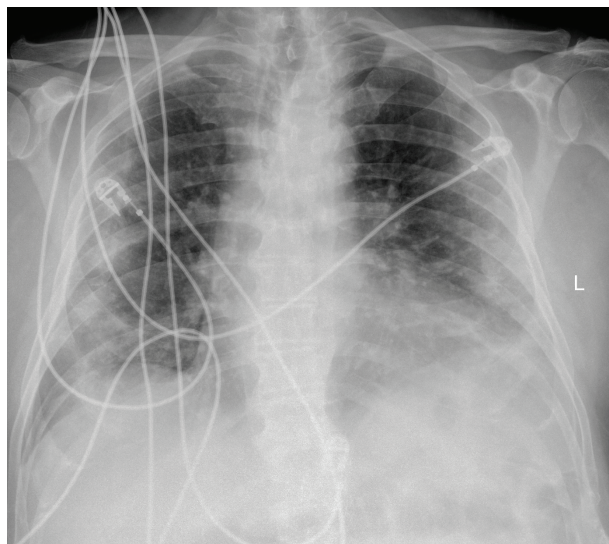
Chest x-ray at admission.
